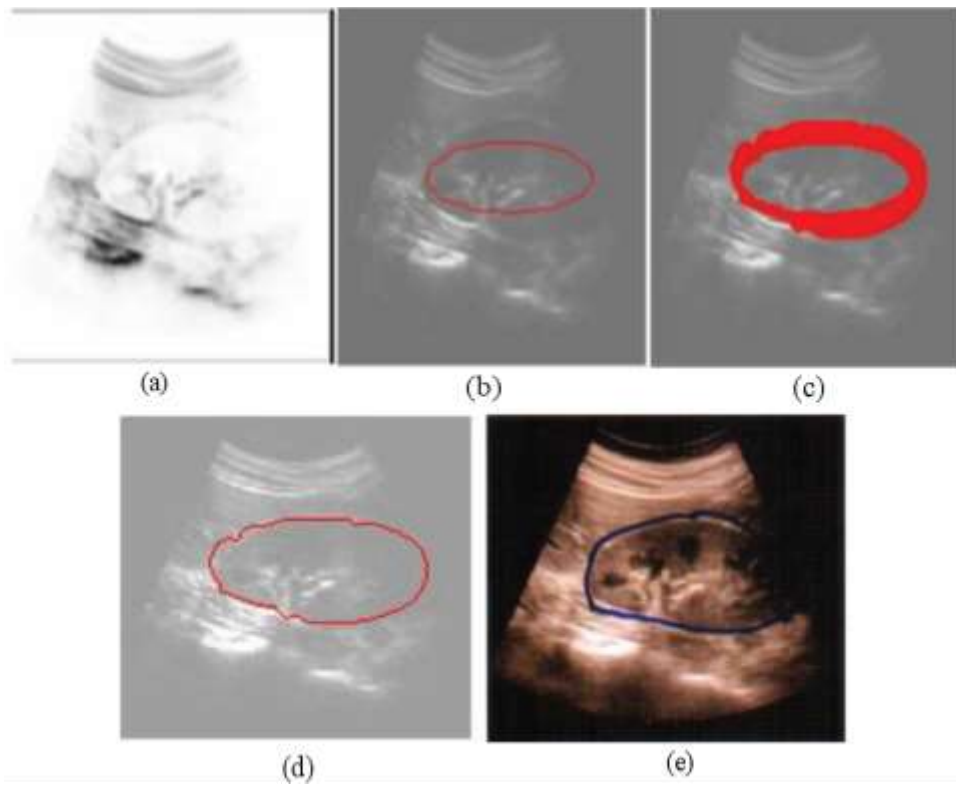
Segmentation of normal kidney using GVF model: (a) Denoised normal kidney ultrasound image (b) User defined initial contour (c) Intermediate deformed image (d) Finally segmented image (e) Manually annotated image by medical expert
